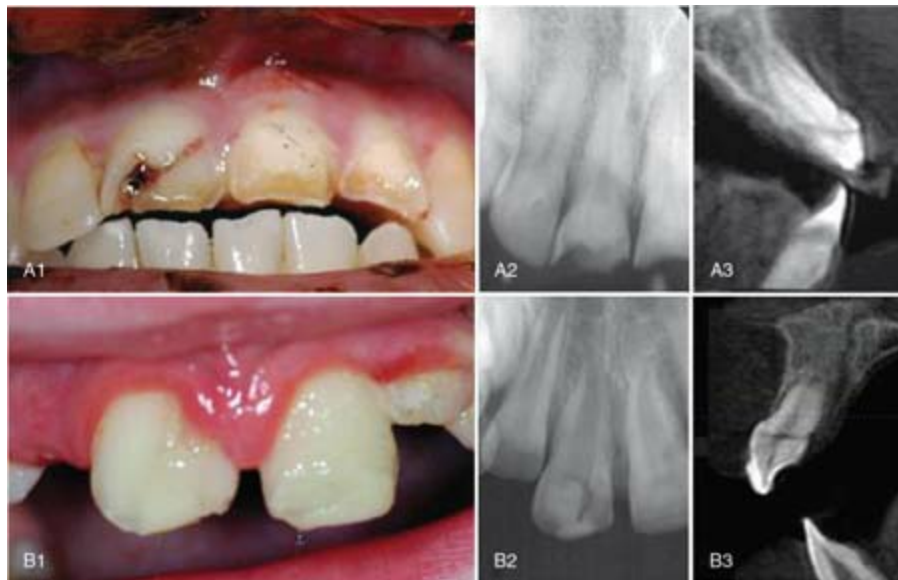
A1, A clinical photograph of a maxillary right central incisor that sustained a crown-root fracture. A2, A periapical radiograph that failed to show the extent of the crown-root fracture. A3, A CBCT image
